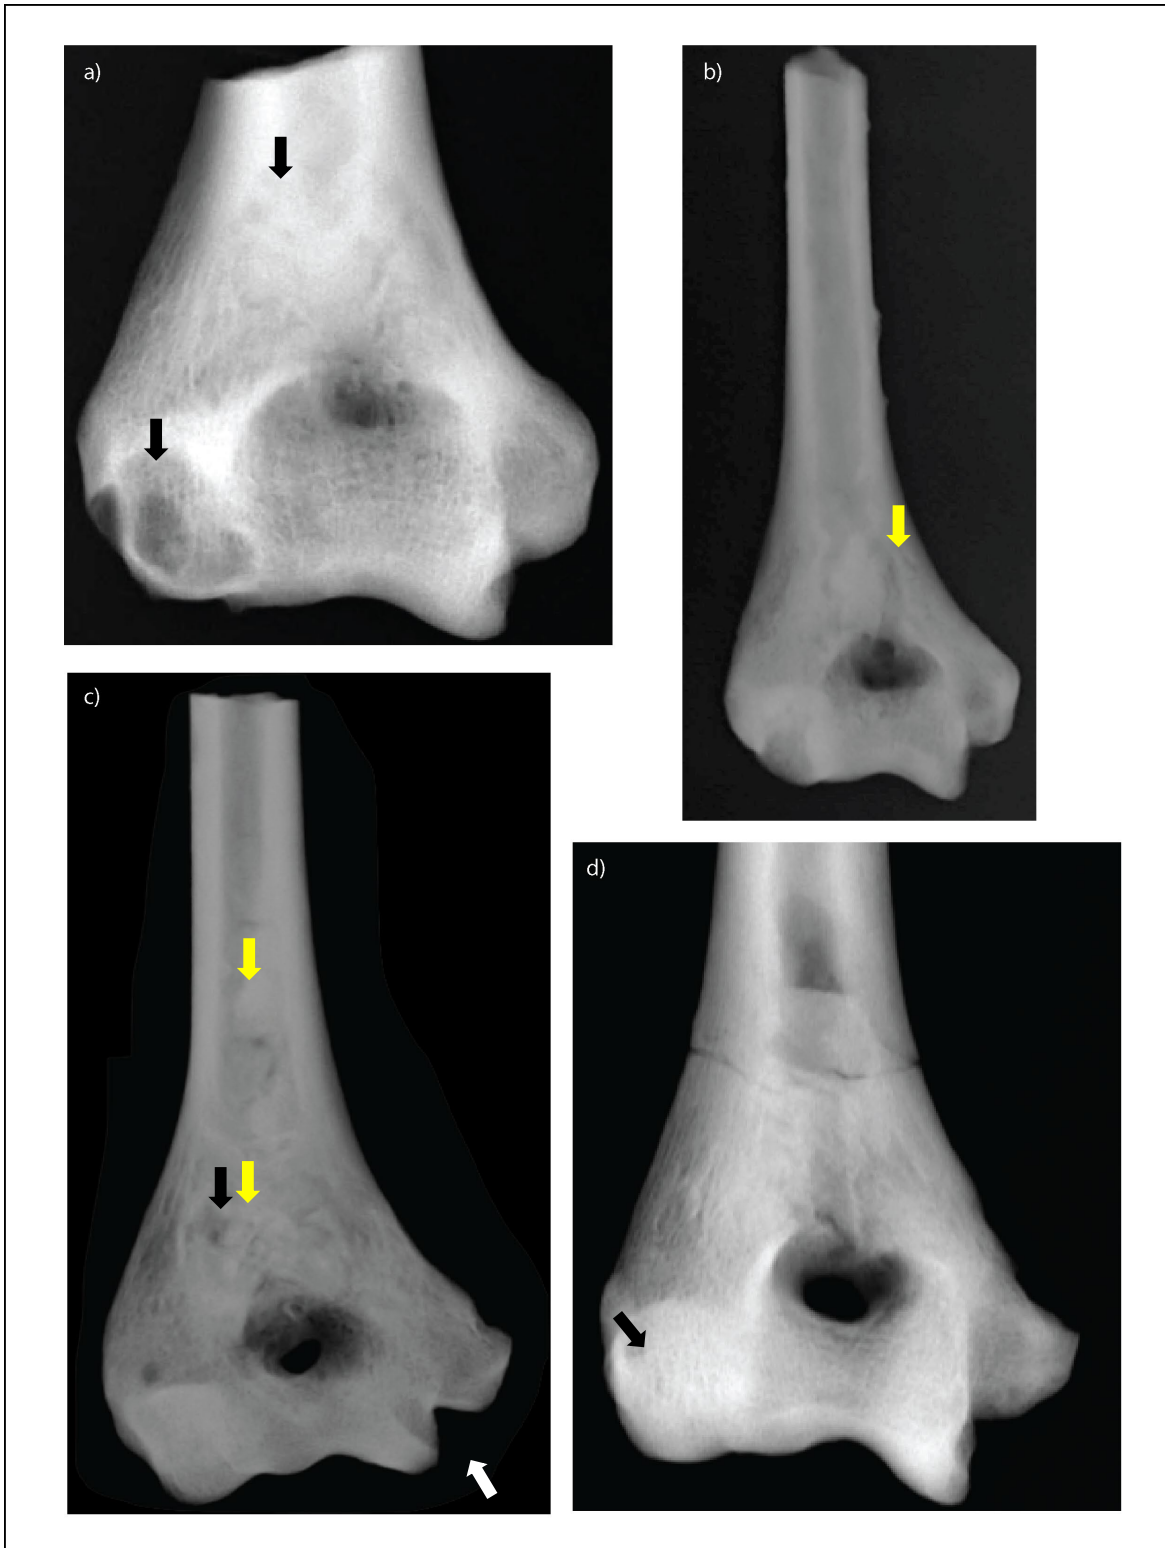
Radiographic signs of hydatids disease at Con Co Ngua. a) Radiographic evidence of small and multilocular lesions throughout the trabeculae terminating in a cortex breach with clear sclerotic margins (black arrows; CCN13M12a, young adult male). b) Ischemic necrosis of the trabecular bone extending from the medullary canal (yellow arrow; CCN13M59a, old adult male). c) Ischemic necrosis of the trabeculae extending from the medullary canal (yellow arrows). There is a large oval radiolucent region which is comprised of small and numerous multilocular lucencies resembling a “bunch of grapes” (black arrow). There is also a pathological fracture which has deformed (depressed) the medial epicondyle (white arrow; CCN13M21a, adult female). d) Two small circular lesions extending into the subchondral bone (CCN13M72a, adolescent to young adult). Image: authors own
